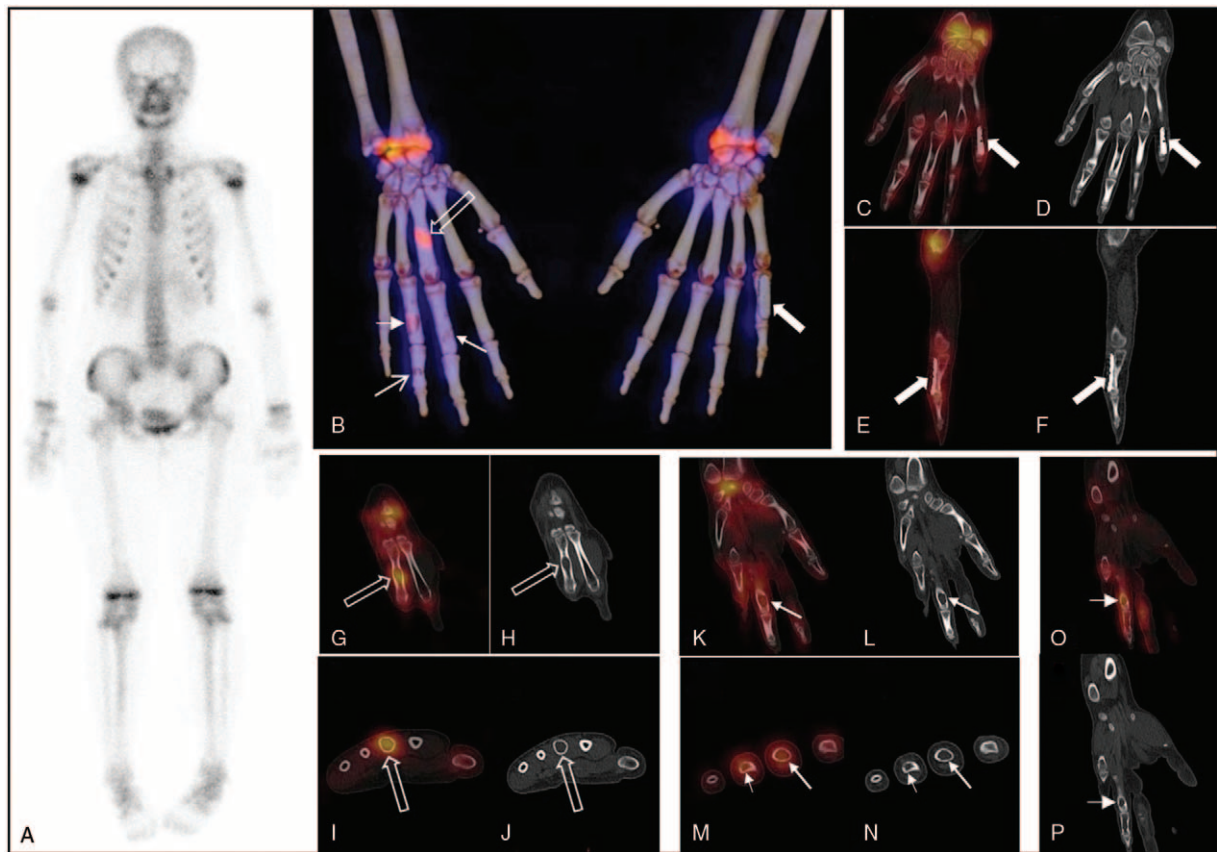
The pre-surgery ^{99m}Tc -MDP SPECT/CT image revealed that the titanium plate on the fifth proximal phalanx of her left hand (the solid bold arrows on B, C, D, E, and F) did not fall off or break. The examination of the right hand revealed expanded lesions and high MDP uptake in the third metacarpal (the hollow thick arrows on G, H, I, and J) and proximal phalanges (the long arrows on K, L, M, and N), as well as the fourth proximal phalanges (the short arrows on M, N, O, and P) and the middle phalanx (the thin arrows on B). Although the number of multiple lesions in her right hand did not change compared with the previous examination a year ago, but clearly expanded while the cortical bone became thinner at the corresponding position and showed high MDP uptake.
